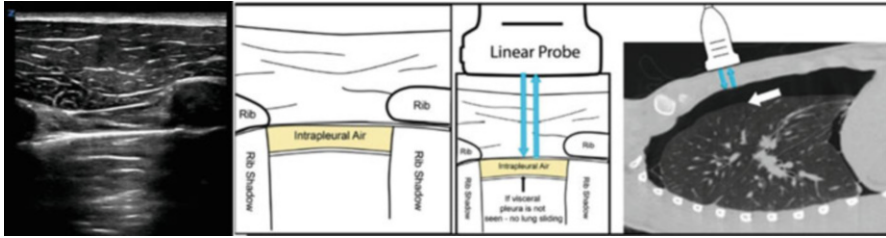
From left to right, free intrapleural air (seen in a pneumothorax) separates the parietal and visceral pleura with resultant loss of the lung sliding artifact. Reverberation artifacts, or A-lines, are still generated by the presence of a tissue-air interface, however. A sagittal computed tomography (CT) scan is also included to demonstrate how free air separates the lung from the chest wall: the arrow indicates the visceral pleura, now separated from the parietal pleura by free air (the radiolucent, darker area above the arrow)
